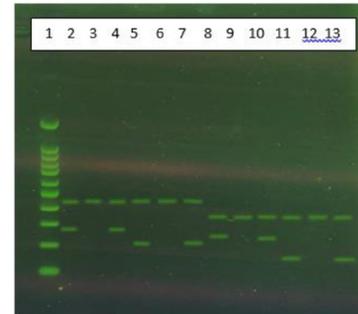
Results of tetra-primer ARMS-PCR for locus rs12478601 polymorphism and locus rs13429458 polymorphism. 1; Marker 100 bp, 2, 3; Homozygous person CC rs13429458, 4, 5; Heterozygous person CA rs13429458, 6, 7; Homozygous person AA rs13429458, 8, 9; Homozygous person TT rs12478601, 10, 11; Heterozygous person CT rs12478601, and 12, 13; Homozygous person CC rs12478601.
